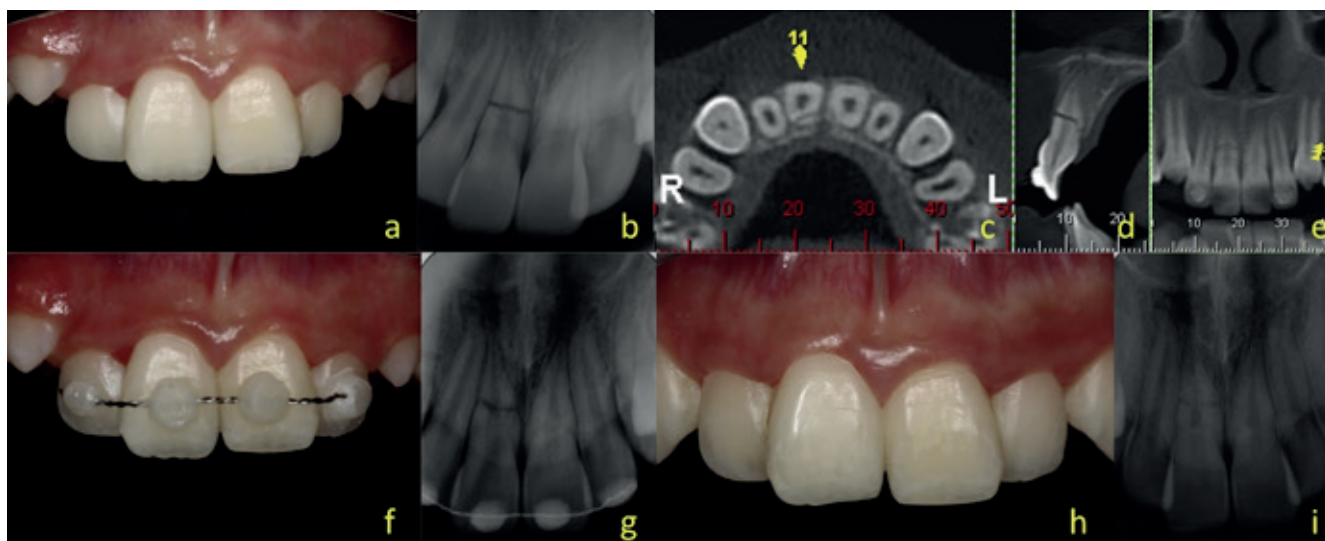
(a) Initial intraoral view of the case 1. (b) A preoperative radiograph showing horizontal root fracture at the apical third of the left maxillary central incisor. (c) CBCT showing the sagittal (d) axial (e) and panoramic view. (f) Semi-rigid splint performed. (g) Periapical radiograph at 4-months. (h) Buccal clinical aspect at 2-year follow-up. (i) Radiographic examination at 24-months.
